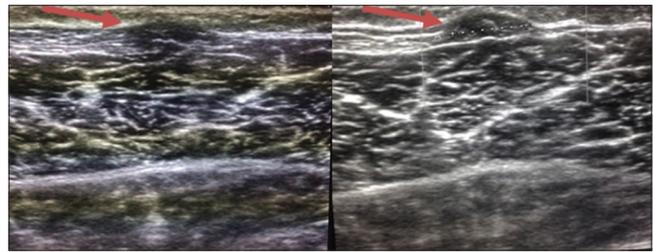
Longitudinal ultrasound image of the anterior tibialis muscle demonstrating focal protrusion of muscle through a fascial defect (red arrow), which is more conspicuous on the second image with muscle contraction.
